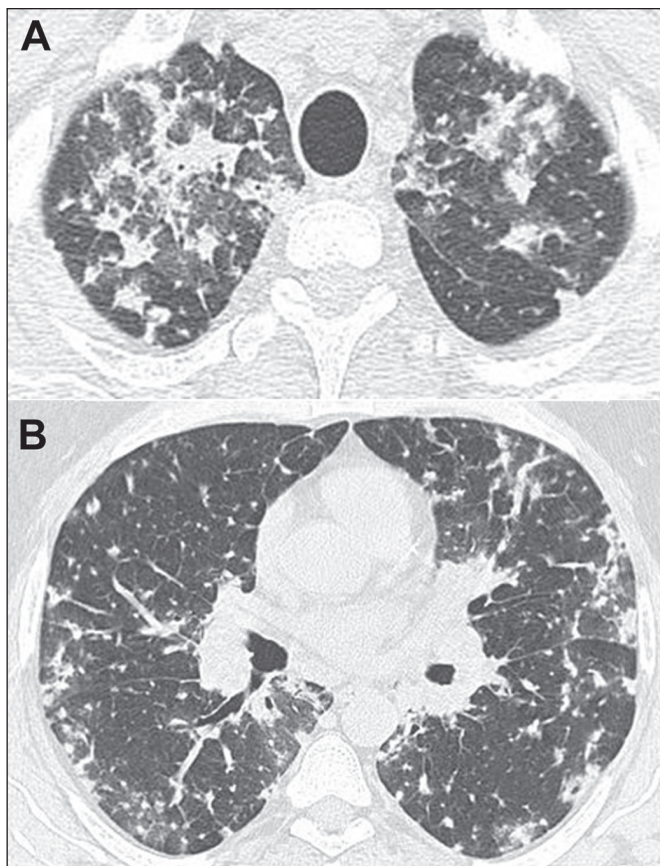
CT of a 57-year-old man with positive serology, showing disseminated histoplasmosis. Note the focal areas of consolidation and ground-glass attenuation, together with small nodules, throughout both lungs.
